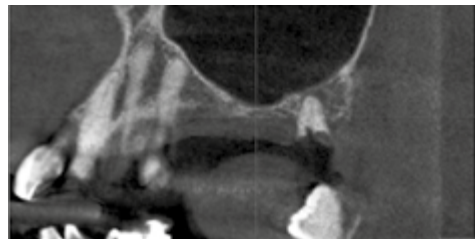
CBCT seno mascellare sinistro (Atrofia classe D).
